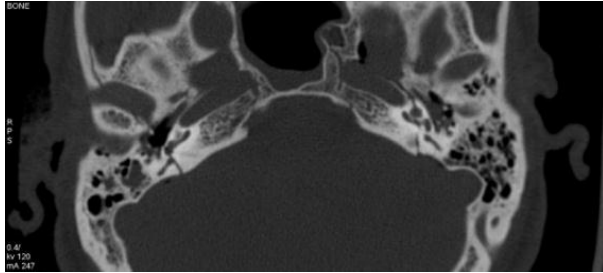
CT scan of temporal bones (axial view) showing bilateral transverse fractures.
